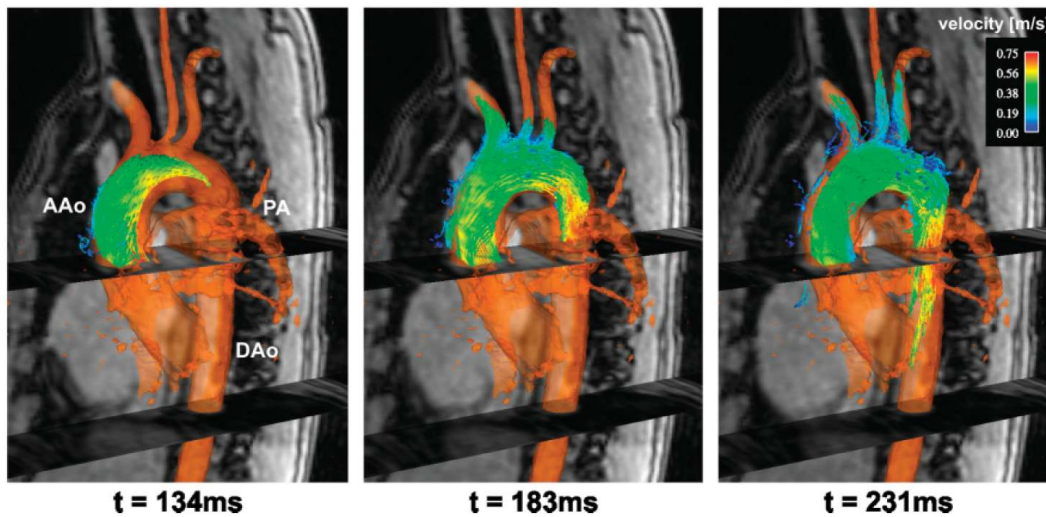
MRI scan of the heart and surrounding vessels showing the blood flow velocity in the aorta in different phases of the systole. (Image source: [Markl 07])
